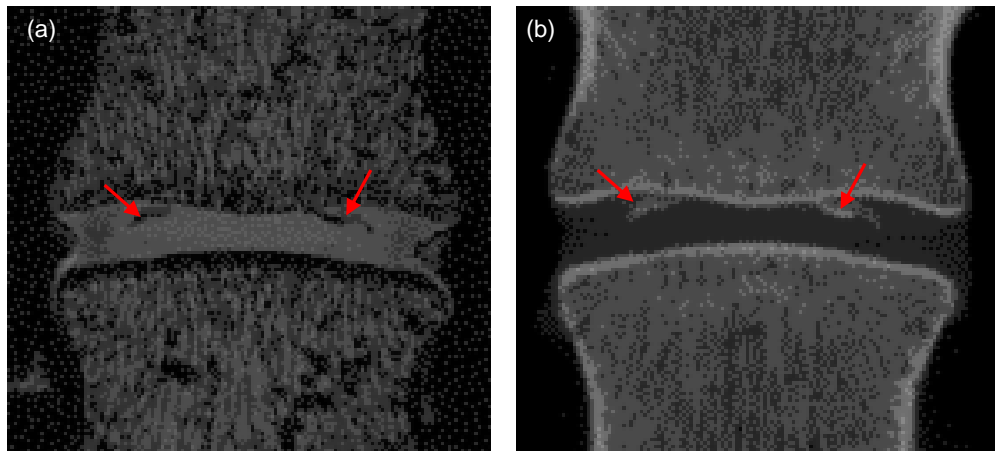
Equivalent coronal slices from the annulus MR scan (a) and  $\mu$ CT scan (b) for S3. The arrows indicate some unusual features showed up in both modalities.
